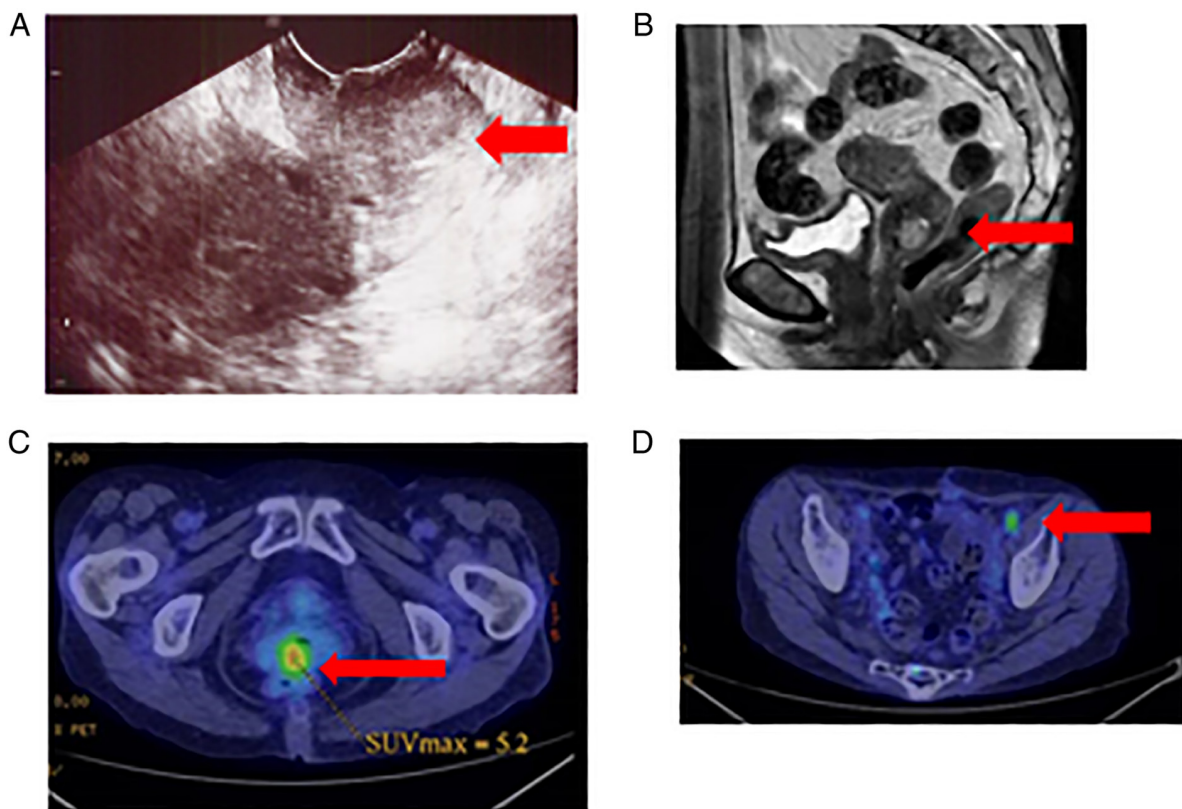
Preoperative examination in this case. (A) Transvaginal ultrasound findings: Tumor of ~2 cm in the cervix. (B) Magnetic resonance imaging revealed a 20-mm mass confined to the uterine cervix area, showing high signal intensity on T2-weighted images. (C) PET/CT scan: PET uptake in the cervix. (D) PET/CT scan: PET uptake in the pelvic lymph node. The lesions are indicated by red arrows. PET, positron emission tomography; CT, computed tomography.
